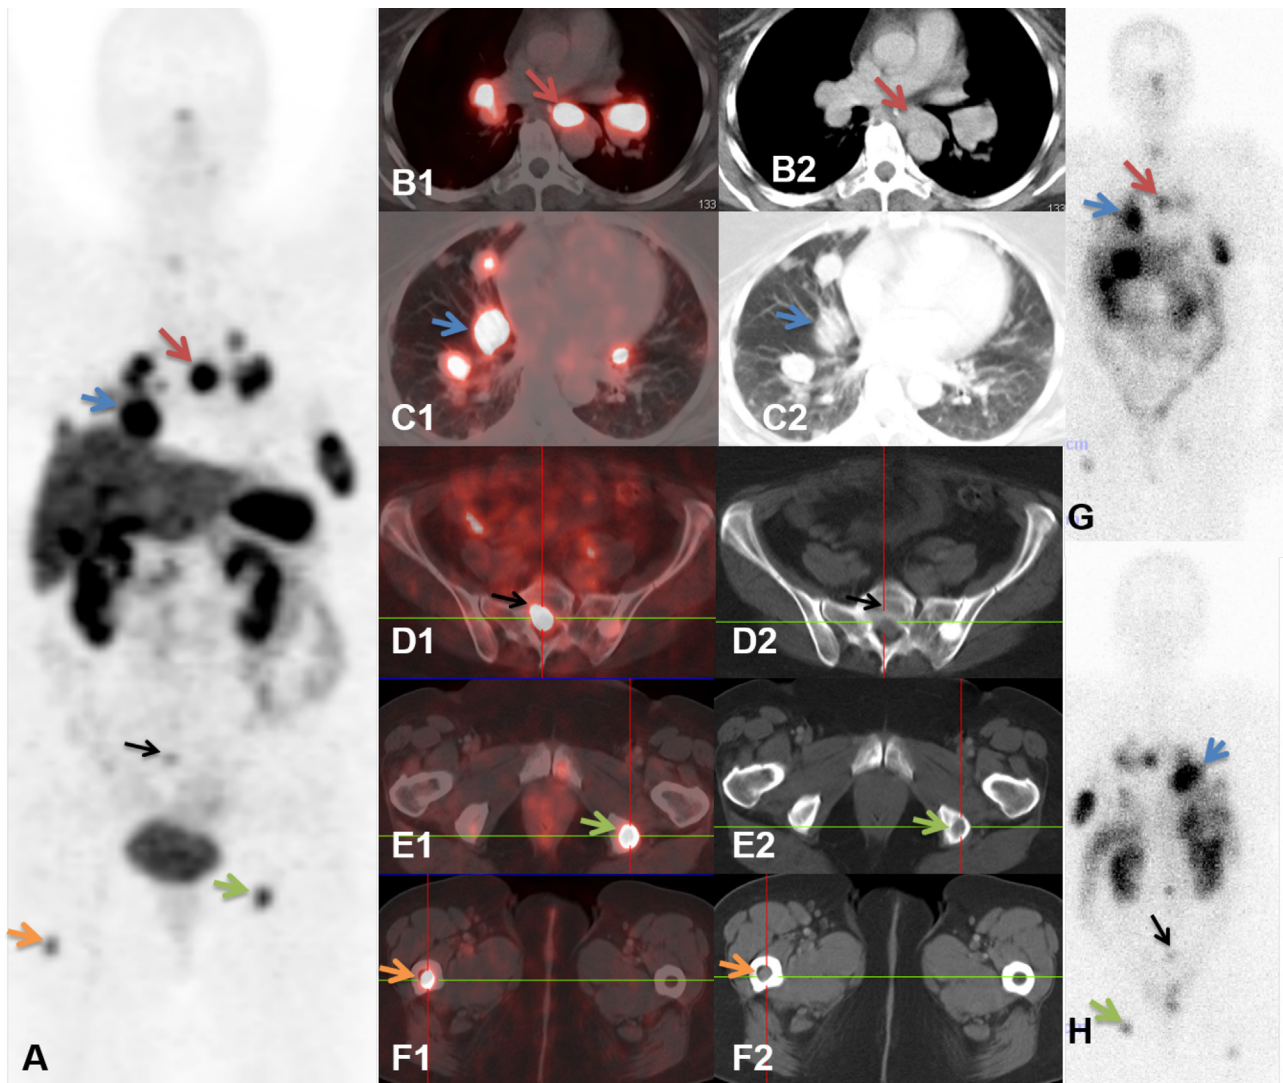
A 43-year-old female with oncocytic follicular carcinoma of the thyroid (initial stage pT4), first diagnosis 10 years back, was referred to our center with progressive lymph node, pulmonary, hepatic, osseous, and cerebral metastases after surgery, external radiation, chemotherapy, and 3 radioiodine therapies. The baseline ^{68}Ga -DOTATOC PET/CT (A-F) revealed intense somatostatin receptor (SSTR) expression in the metastases, which provided a theranostic basis for the administration of peptide receptor radionuclide therapy (PRRT). Intense uptake was demonstrated on PET/CT (A—MIP, B1-F1—PET/CT transverse images, and B2-F2—corresponding CT transverse images) in mediastinal lymph node (B—red arrow), lung (C—blue arrow), sacrum (D—black arrow), left ischium (E—green arrow), and right femur (F—orange arrow) which is also seen on ^{177}Lu -DOTATATE posttherapy whole-body scans (G—in anterior view; and H, in posterior view).
